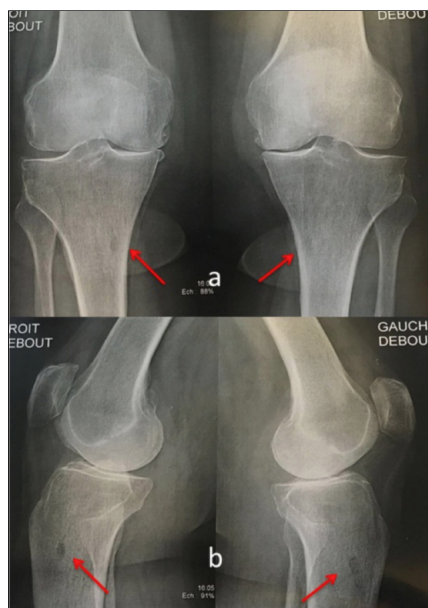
Initial anterior-posterior (a) and lateral (b) x-rays of a 65 year-old a woman taken after procedure. Red arrows showing drilling holes.
